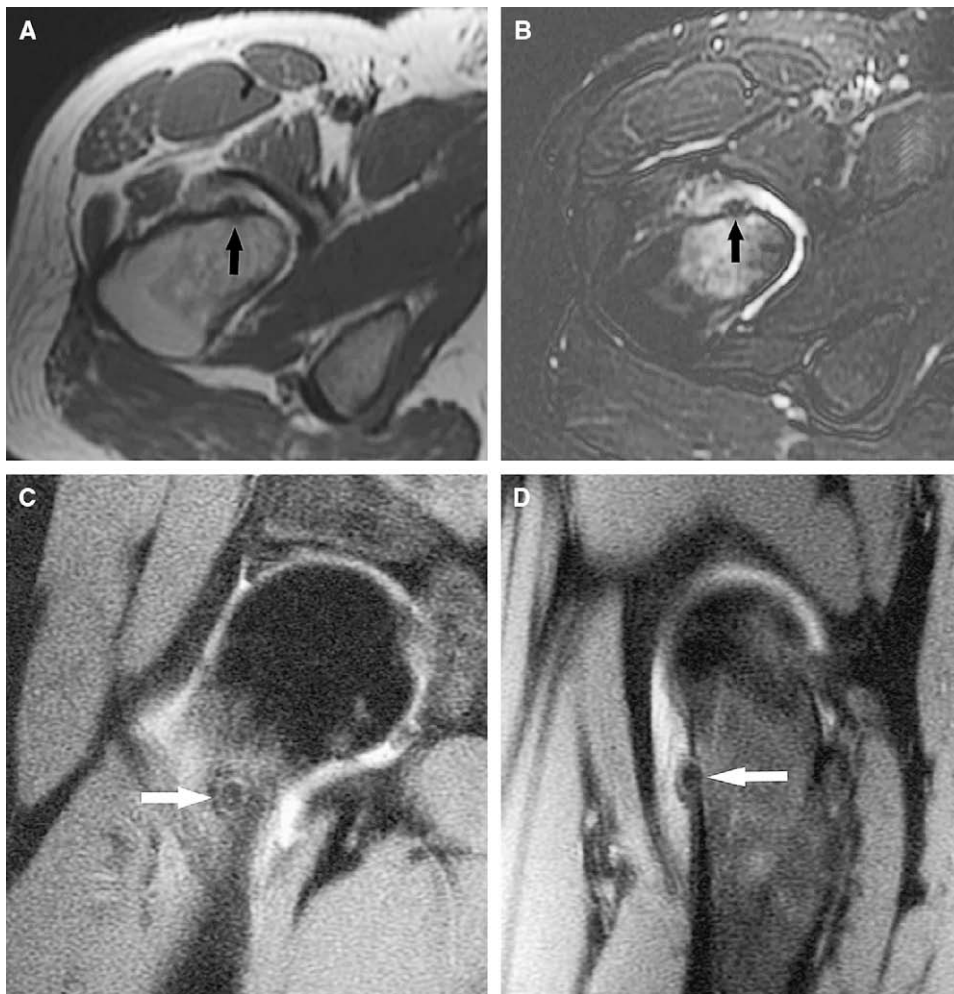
Magnetic resonance imaging shows the center of the lesion to be of low signal on both (A) T1W and (B) T2W images in keeping with mineralization. This is surrounded by intermediate-signal rim on (C and D) fat suppressed proton density weighted images, which represents the noncalcified rim of the nidus. High signal seen on the (B) fat-suppressed T2W image surrounding the nidus is consistent with marrow oedema. A small hip joint effusion also is present.
